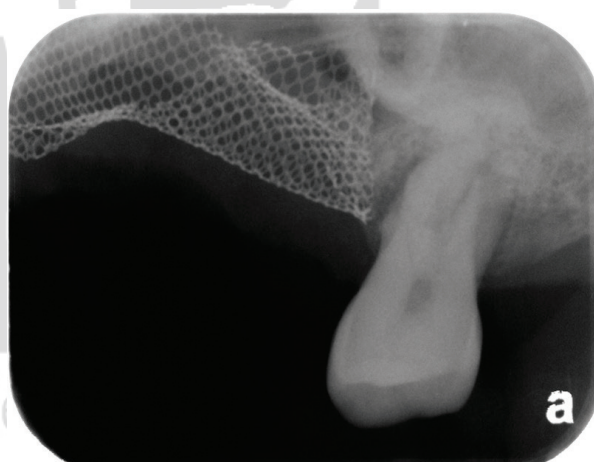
Periapical film of the maxillary left second molar.
